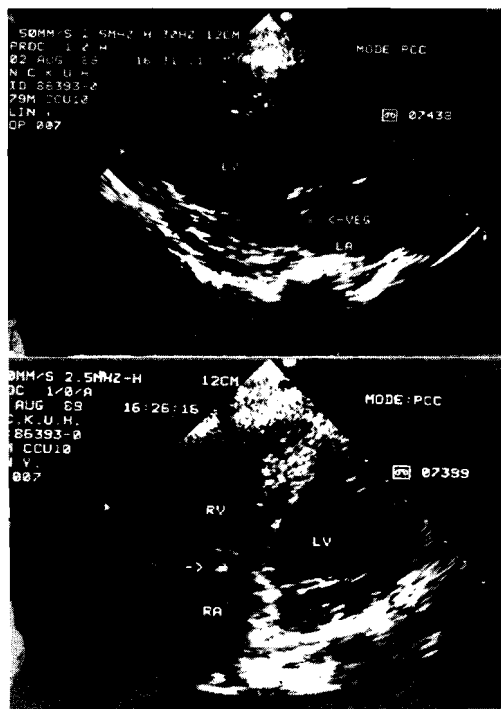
A, B : Vegetations (arrow) over mitral valve (A) and tricuspid valve (B) noted 7 days later. (A : parasternal long axis view. B : apical four chamber view)
